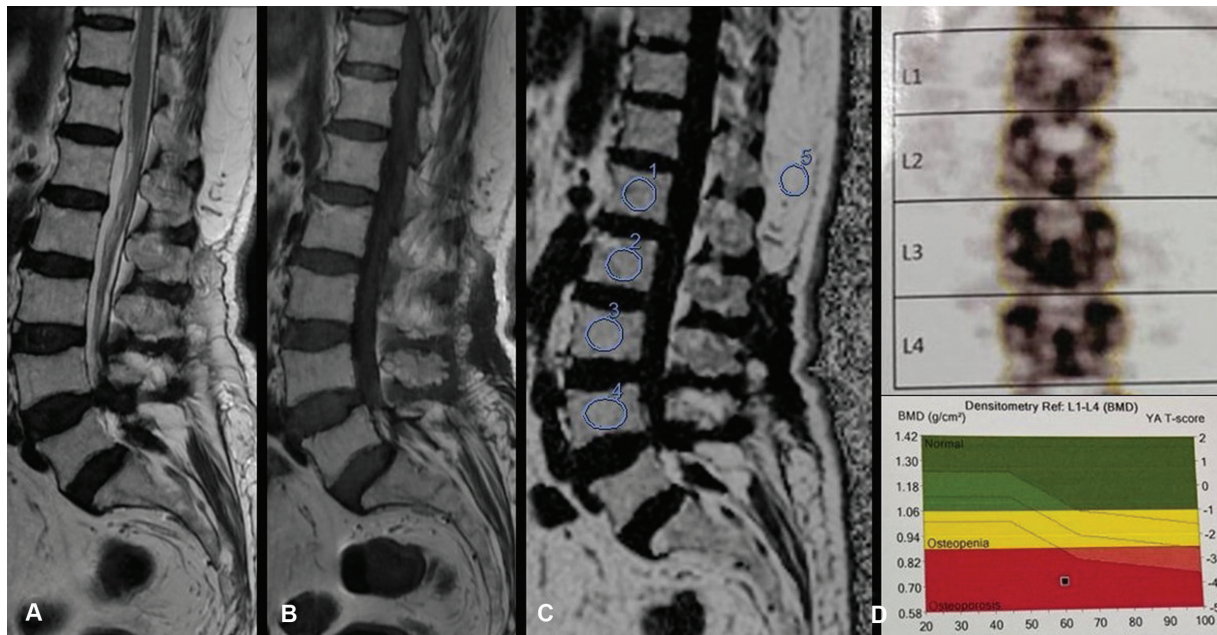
Magnetic resonance imaging (MRI) lumbosacral spine and bone mineral density (BMD) in a 65-year-old female patient presenting with low backache. Routine T2-weighted imaging (T2WI) (A) and T1WI (B) show intervertebral disc desiccation at all levels and marginal osteophytes. Fat fraction (72) was obtained from iterative decomposition of water and fat with echo asymmetry and least-squares estimation-intelligence quotient (IDEAL-IQ) sequence. T-score of -3.9 was obtained from dual-energy X-ray absorptiometry (DXA) (D).
